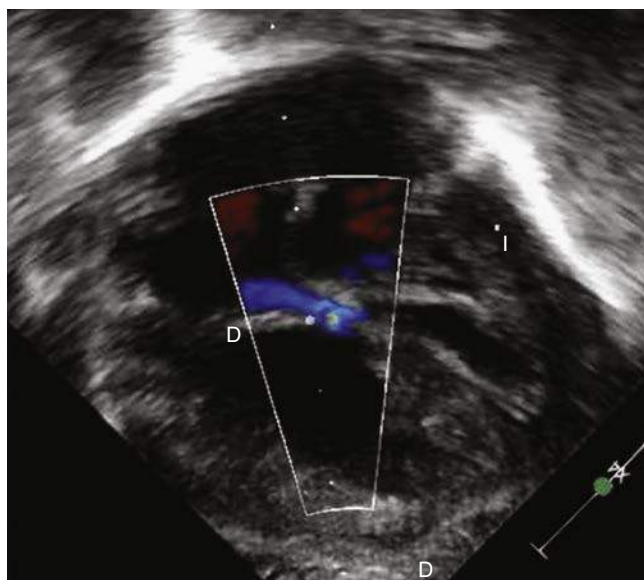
Gerbode defect. Apical four-chamber transthoracic echo view with color Doppler demonstrating a Gerbode defect (LV-to-RA shunt). Anderson and colleagues consider some Gerbode defects to be on the spectrum of atrioventricular septal defects (AVSDs). LA, Left atrium; RA, right atrium; LV, left ventricle; RV, right ventricle.
